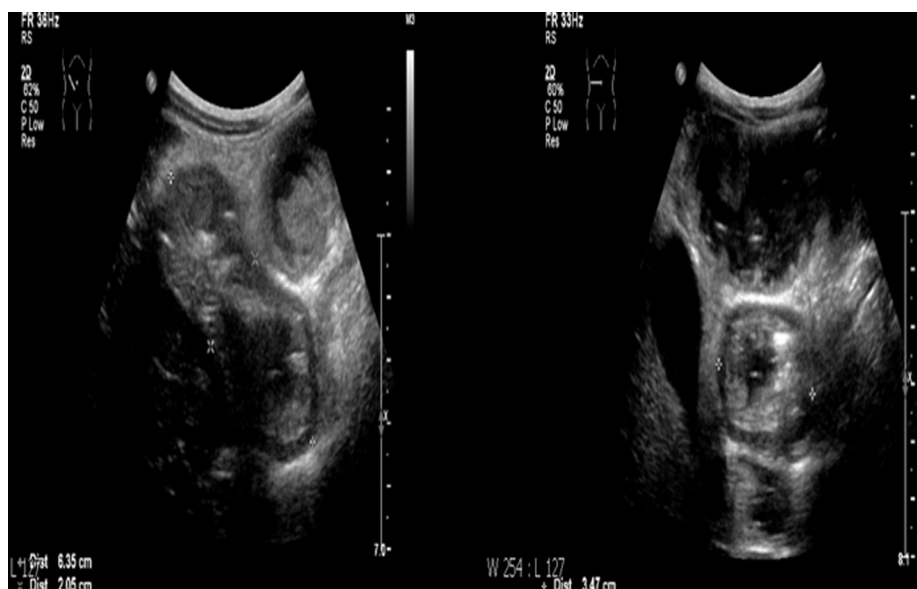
Ultrasound showing intraluminal heterogeneous mass in the bowel lumen.
